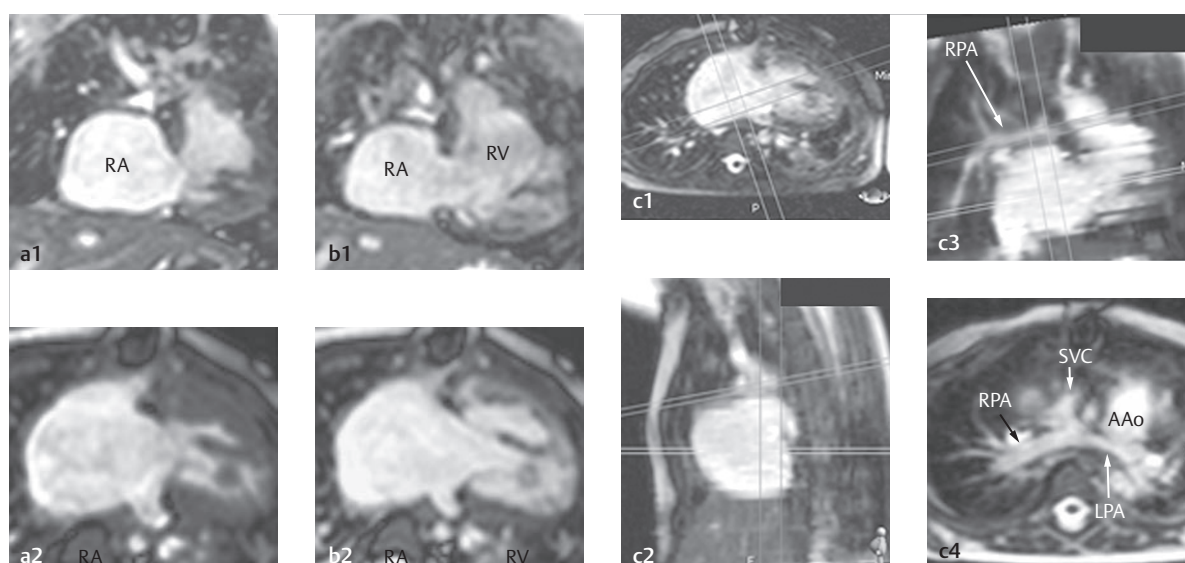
Norwood II operation in a case of HLHS. SSFP MRI of a 10-month-old boy, 4 weeks after the Norwood II operation (► Fig. 4.109b) and placement of a bidirectional Glenn anastomosis of the superior vena cava in the right pulmonary artery. The cine MRIs (a, b) indicate good ventricular function. The 3-D data set was reformatted in a multiplanar fashion in order to depict the Glenn anastomosis (c).
